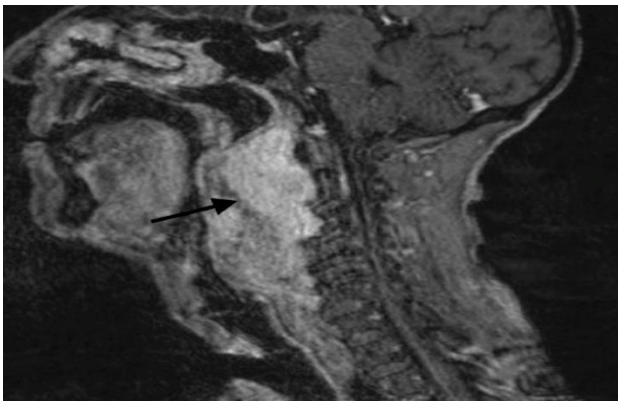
T2-weighted MRI neck showing a large hyperintense lesion (arrow) involving the retropharyngeal and prevertebral space extending from the skull base to the lower border of C6 vertebra.
